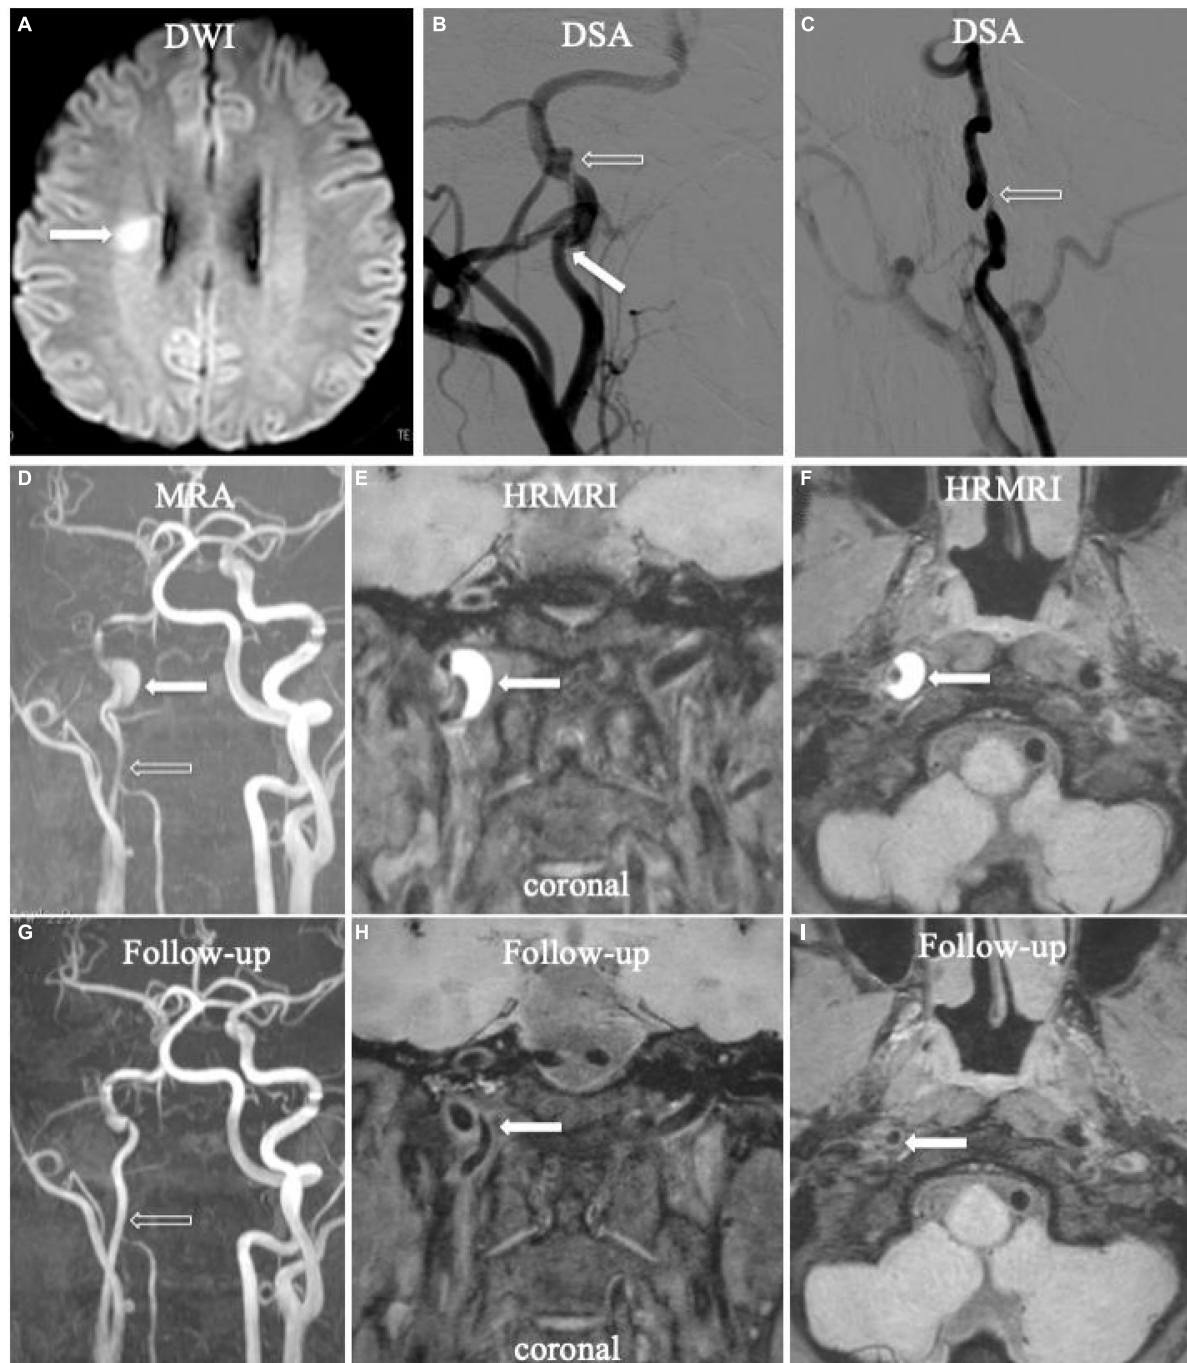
Acute ischemic stroke (A, arrow) in the territory of the right ICA. Digital subtraction angiography (DSA) showed aneurysmal dilation with focal stenosis (B,C, empty arrow) and suspicious intimal flap (B, arrow) in the right ICA. Initial MRA displayed tapered stenosis (D, empty arrow) and a suspicious hematoma (D, arrow). Initial HRMRI showed an intramural hematoma on the T1-weighted coronal (E, arrow) and transverse image (F, arrow). Follow-up MRA (G, arrow) showed partial recanalization on the affected arterial lumen. The intramural hematoma had disappeared on follow-up T1-weighted coronal (H, arrow) and transverse (I, arrow) HRMRI.
